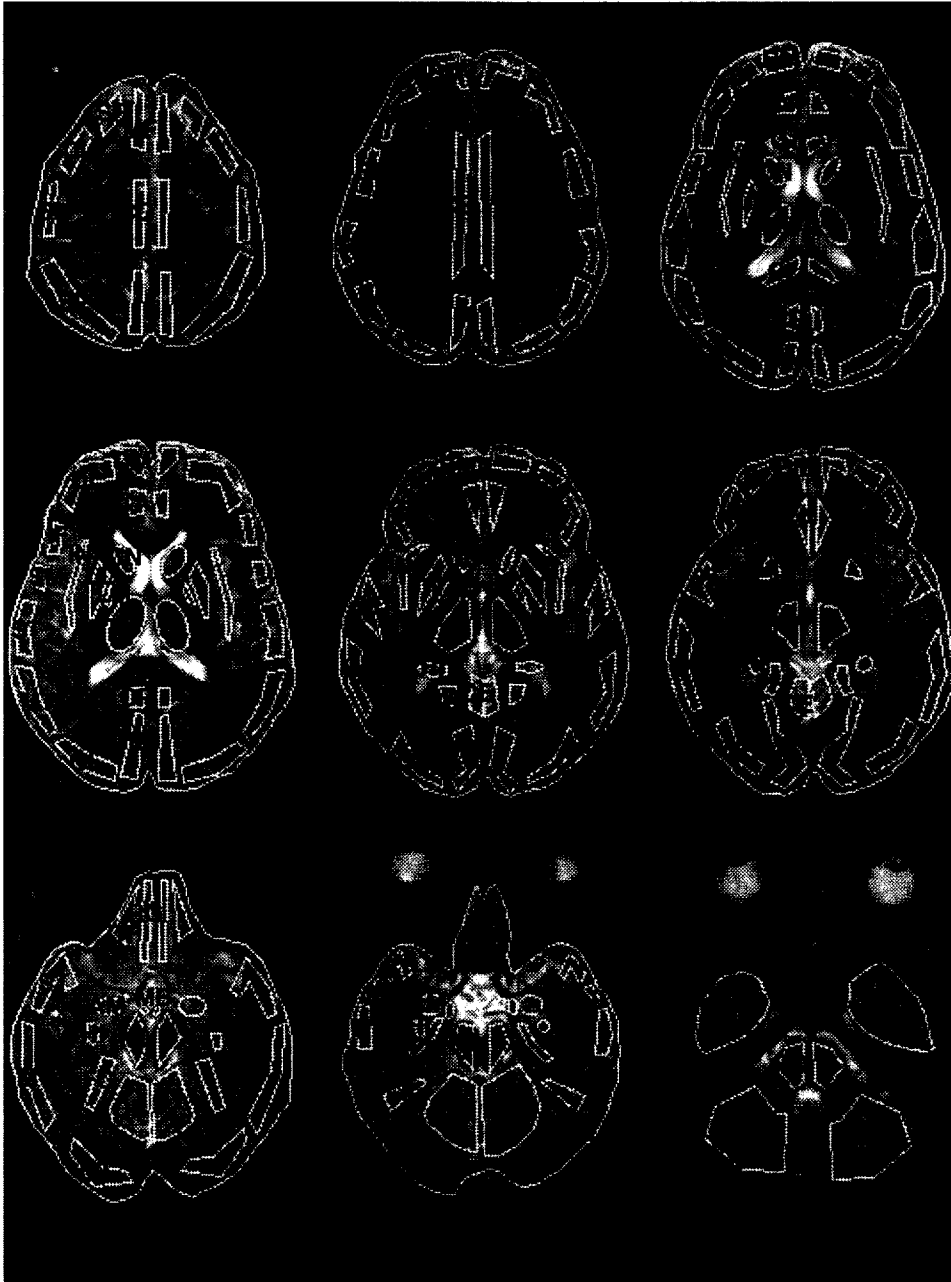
Representative MRI images and corresponding ROIs. (Reprinted with permission from *Science* 1995;267:528-531. Copyright 1995 American Association for the Advancement of Science.)
